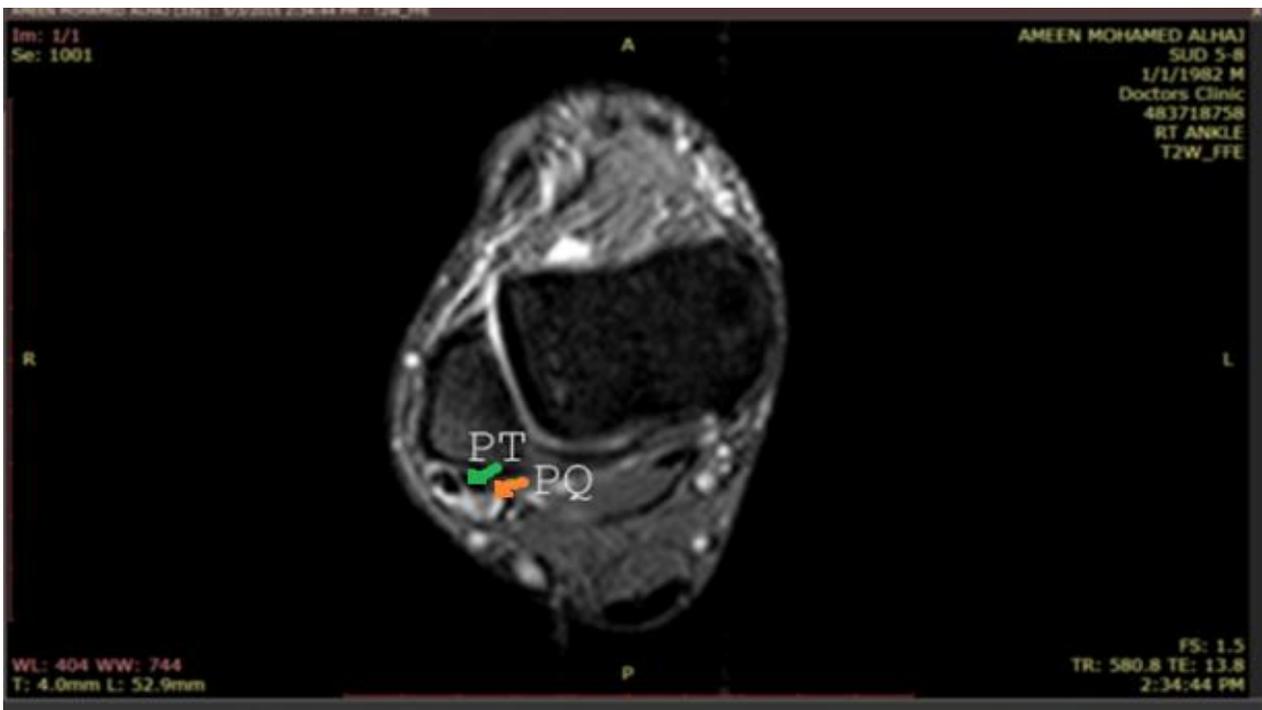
MRI T2W axial cut of the right ankle of female subjects shows the presence of PQ and PT muscle (red and green arrows respectively).
